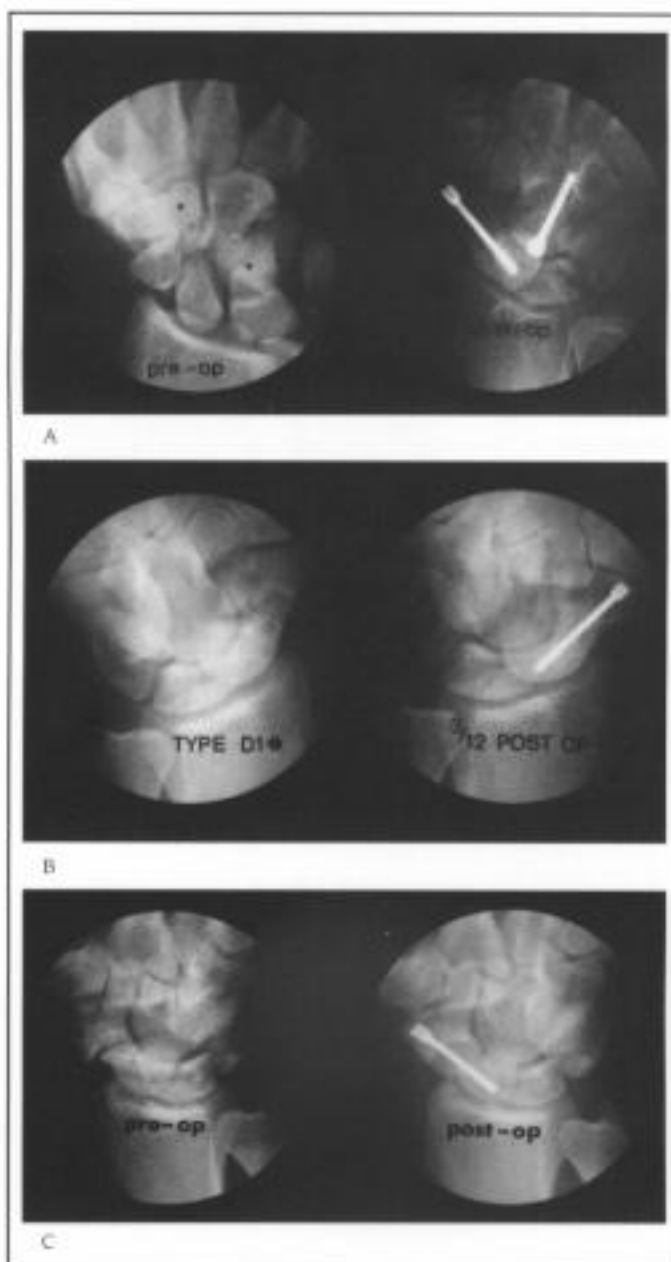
Radiographs showing:
